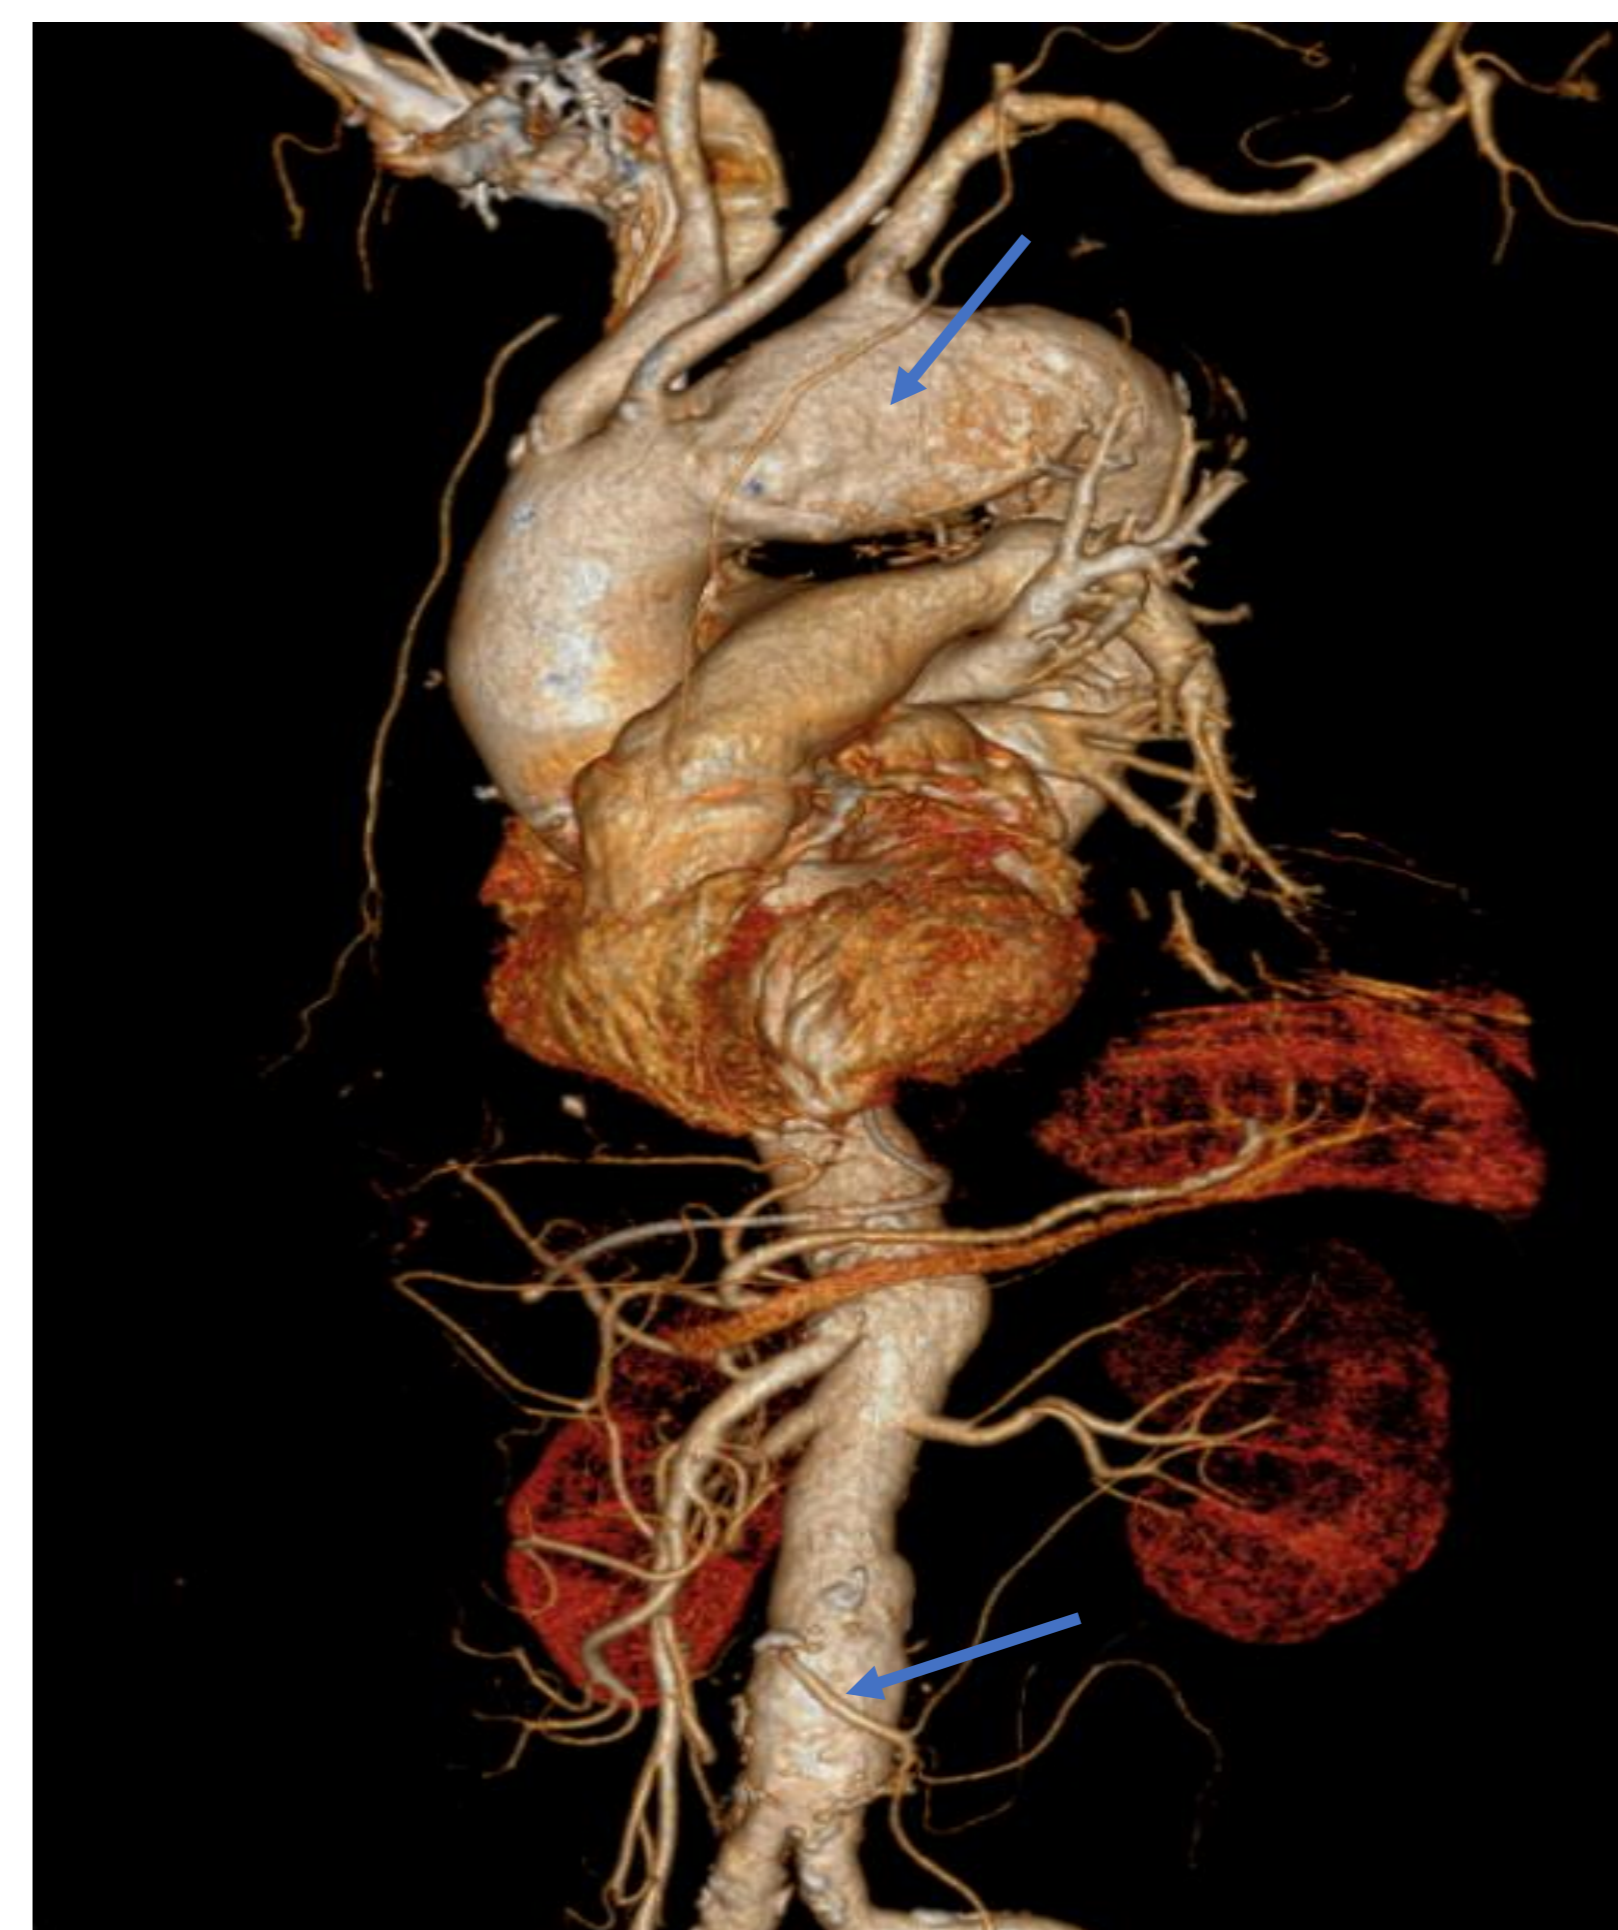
3D volume-rendered CT angiogram. The dissection and aneurysmal changes extend from the ascending aorta through the descending thoracic segment to the abdominal aorta.
